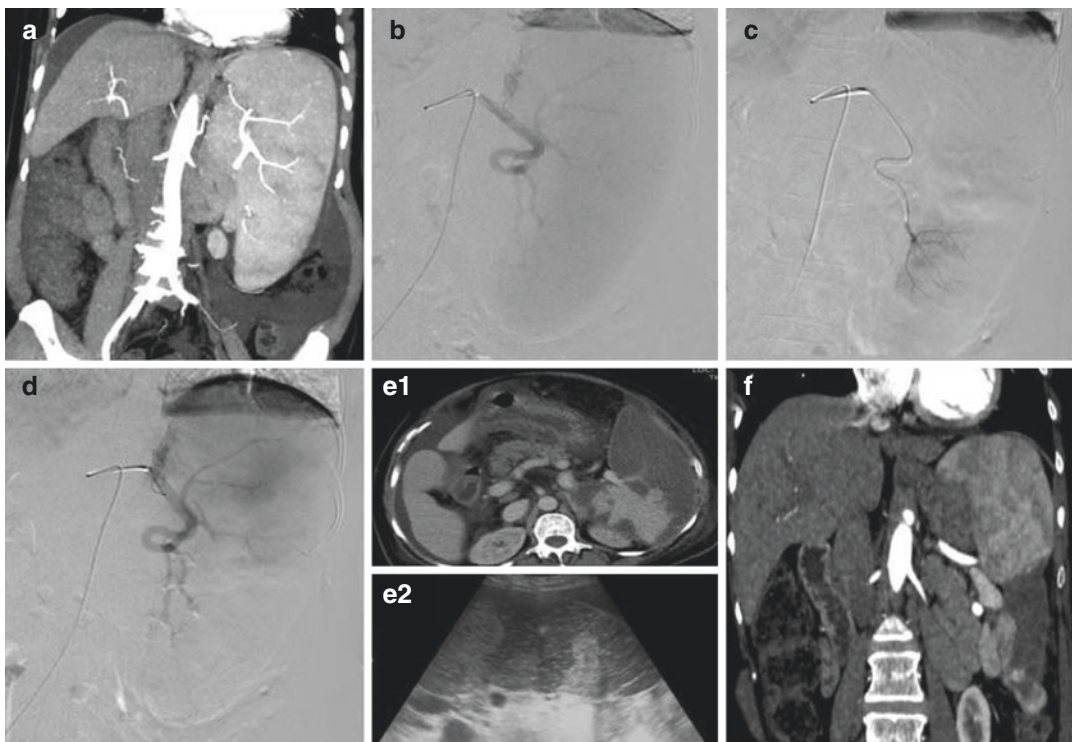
Selective partial splenic embolization—CT abdomen arterial phase coronal image (a), showing cirrhotic liver with gross splenomegaly and moderate ascites. Initial baseline splenic angiographic images (b) delineated the anatomy of splenic artery and parenchymal blush. Super selective angiogram image (c) using microcatheter and final check splenic angiographic images
